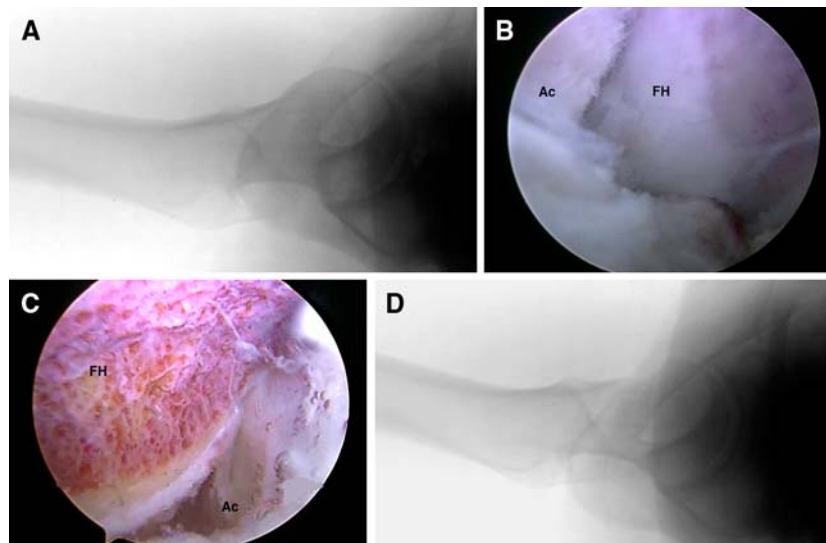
A 27-year-old professional hockey player was evaluated for right hip pain. a A pre-operative cross-table lateral radiograph demonstrated convexity at the anterior femoral head–neck junction. b The presence of a cam lesion was verified arthroscopically. The femoral head (FH) and acetabulum (Ac) are visualized in the peripheral hip compartment with the camera in the anterior portal.
